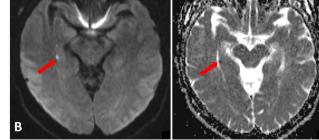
Diffusion restriction on hippocampus, DWI-MRI, B1000 images. A Bilateral diffusion restriction (red arrows) as a hyperintense lesion on B1000 sequence with a corresponding hypointense
